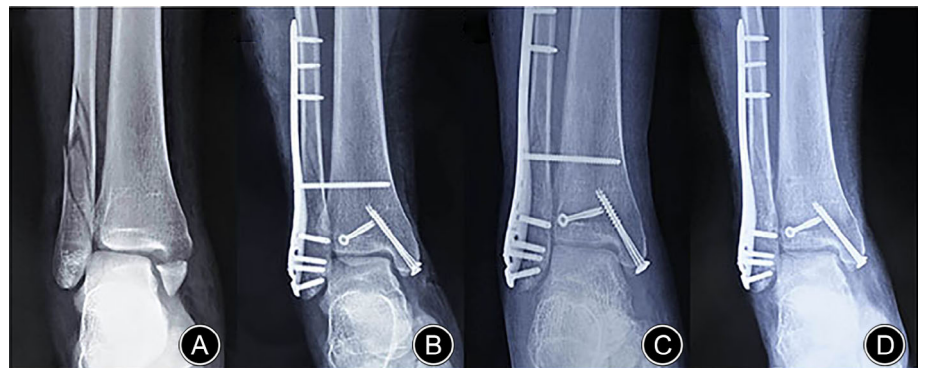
Radiographic images of a patient with the syndesmotom screw placed at the level of 3.6 cm (>3 cm). (A) Radiographic image taken before surgery. (B) Radiographic image taken after surgery. (C) Radiographic image taken before the removal of syndesmotom screw. (D) Radiographic image taken after the removal of syndesmotom screw
